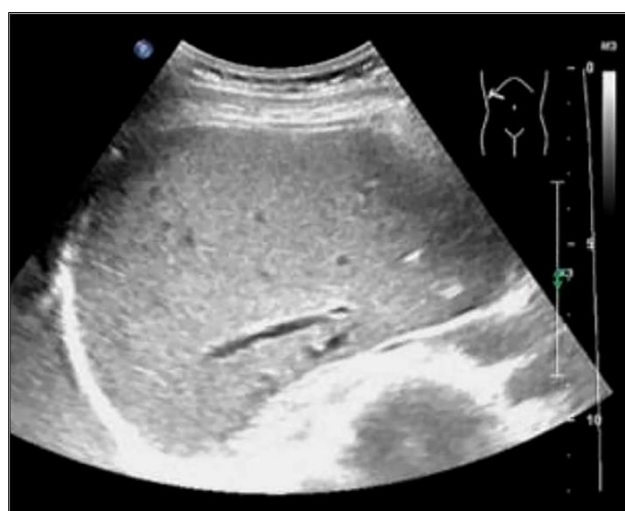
Liver ultrasound of the patient, performed 3 months after surgery. The liver surface was smooth, the liver margin was sharp, and no obvious lesions were found where the hematoma had been detected by computed tomography scan during hospitalization, suggesting that the patient's subcapsular liver hematoma and gas accumulation had been completely absorbed
